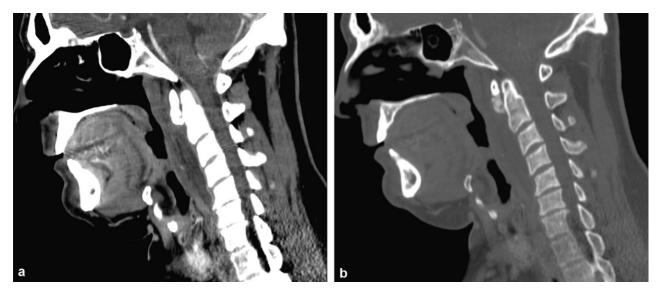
Sagittal CT sections of the cervical vertebra in soft part window (a) and in bone window (b).
